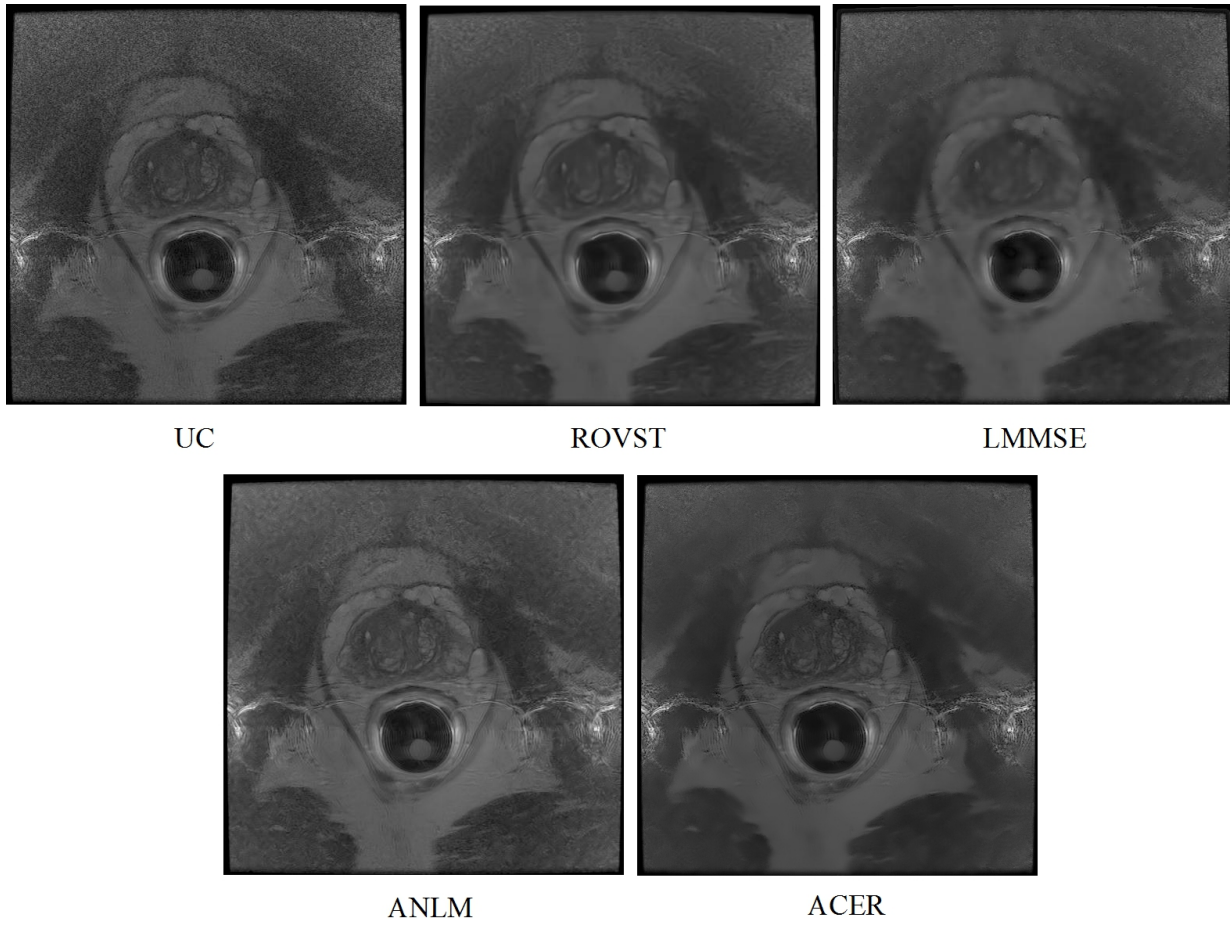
Case 12: A central T2 MRI slice from a patient imaged using a Hologic rigid ERC with moderate noise compensated by various approaches. ACER maintains the detail within the prostate while compensating for the background noise.
